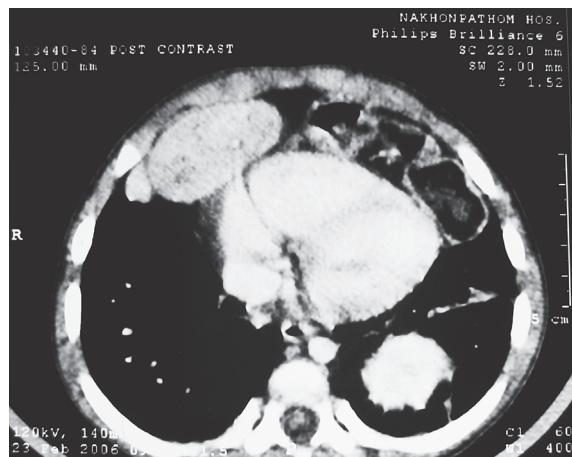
A mass in the right lower lung field with a feeding vessel from the abdomen, left parasternal hernia and suspected of left posterolateral diaphragmatic hernia in the CT scan
